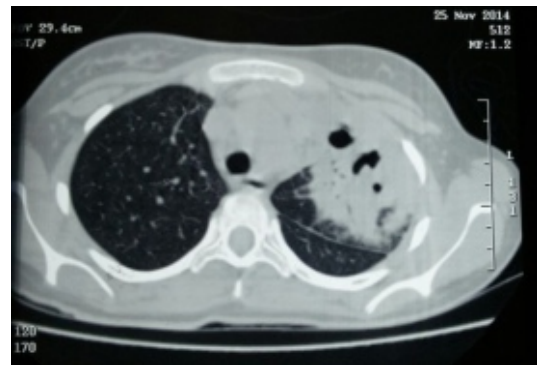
HRCT showing Consolidation with Cavitations in Left Upper Lung Lobe
